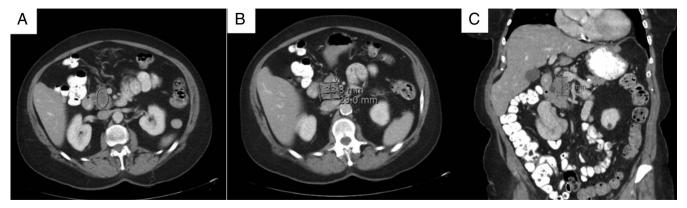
(A–C) Abdominal CT scan with IV and PO contrast revealing a pancreatic hemangioma measuring $3.5 \times 3.4 \times 3.0$ cm in size. CT, computed tomography; IV, intravenous; PO, per os.
